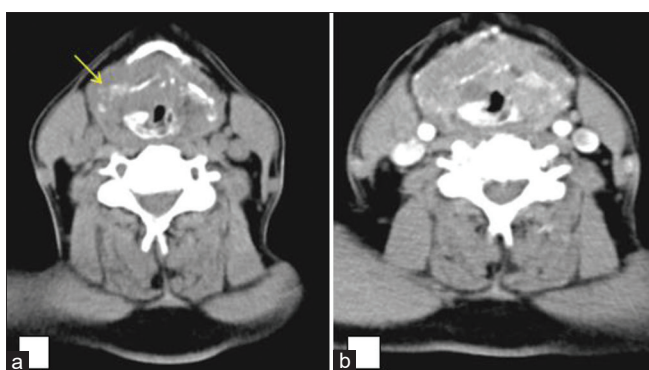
Laryngeal carcinoma. (a) Non-contrast CT axial image shows ill-defined soft tissue density lesion in larynx destroying thyroid and cricoid cartilages. (b) Axial contrast CT image shows heterogeneously enhancing soft tissue density lesion in larynx causing destruction of thyroid and cricoid cartilages
